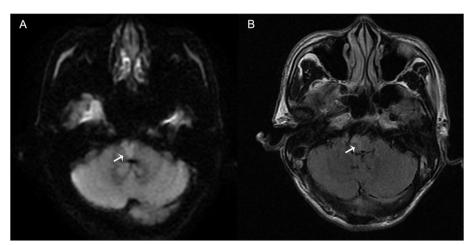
Results of head magnetic resonance imaging performed in the emergency department. Diffusion-weighted imaging sequence (A) showed bilateral medial medullary infarction, and the T2 fluid attenuated inversion recovery sequence (B) revealed medial medullary infarction. The arrows indicated the infarction areas
